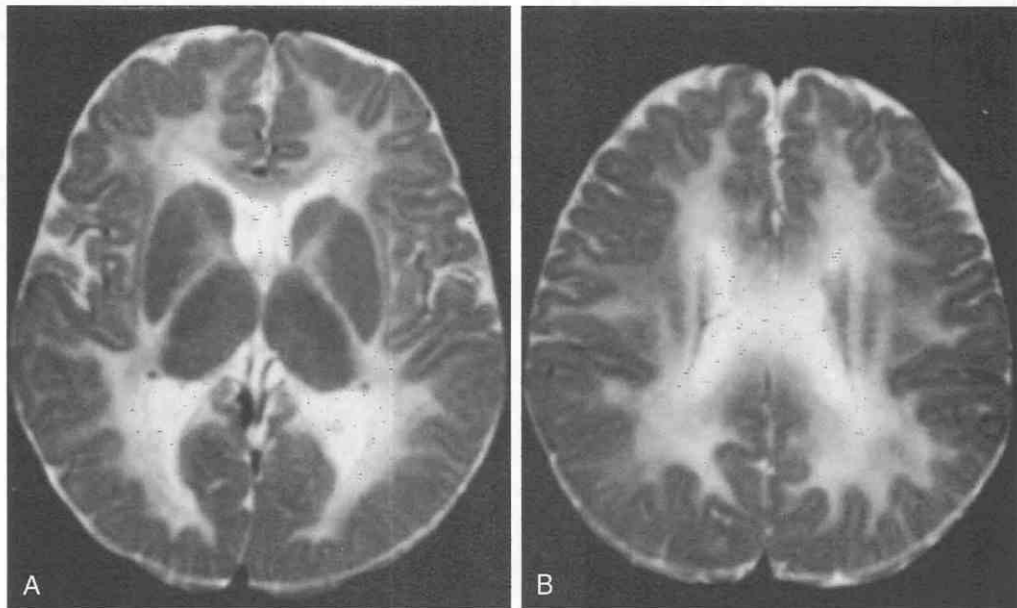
Mitochondrial depletion syndrome in an 8-month-old boy with hypoglycemia, liver failure, and pancreatic insufficiency. A and B, Cranial MR axial T2-weighted images. There is hyperintensity of virtually the entire cerebral white matter, including internal and external capsules, compatible with severe hypomyelination and demyelination.
